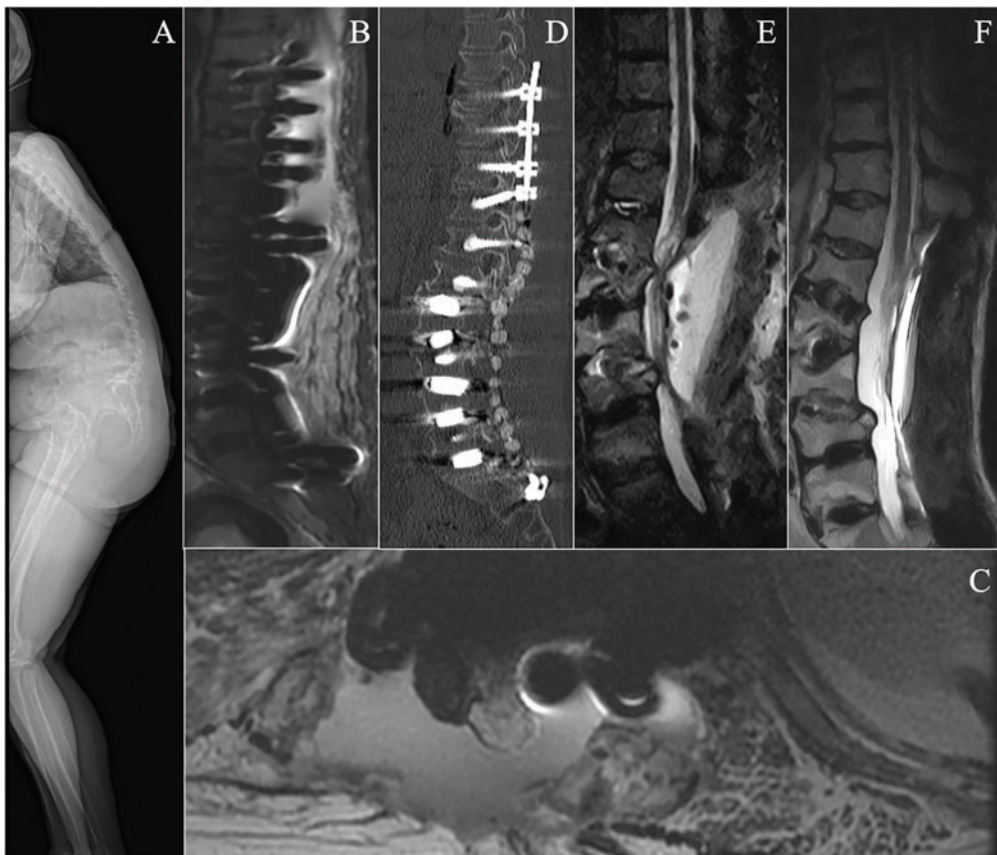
Imaging findings of the patient. (A) Preoperative standing full-body radiograph; (B and C) STIR sequence and T2-weighted MRI taken the day after the second debridement surgery; (D) sagittal CT showing cement beads in place; (E) MRI STIR sequence showing fluid signal at the surgical site before the final debridement surgery; and (F) T2-weighted MRI showing improvement at the infection site before discharge.
